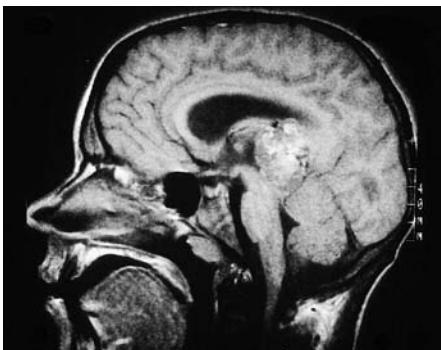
Sagittal T1-weighted MRI of a teratoma in the pineal region, occupying the dorsal aspect of the third ventricle.
